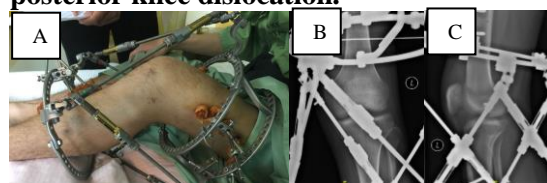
Post reduction knee photograph and plain radiographs of the same patient. (A) The photograph demonstrates gross anterior tibial translation compared to Figure 1(A). Ortho-SUV frame is currently in passive range of motion training mode. (B) AP view and (C) lateral view plain radiographs showing reduced knee joint.
